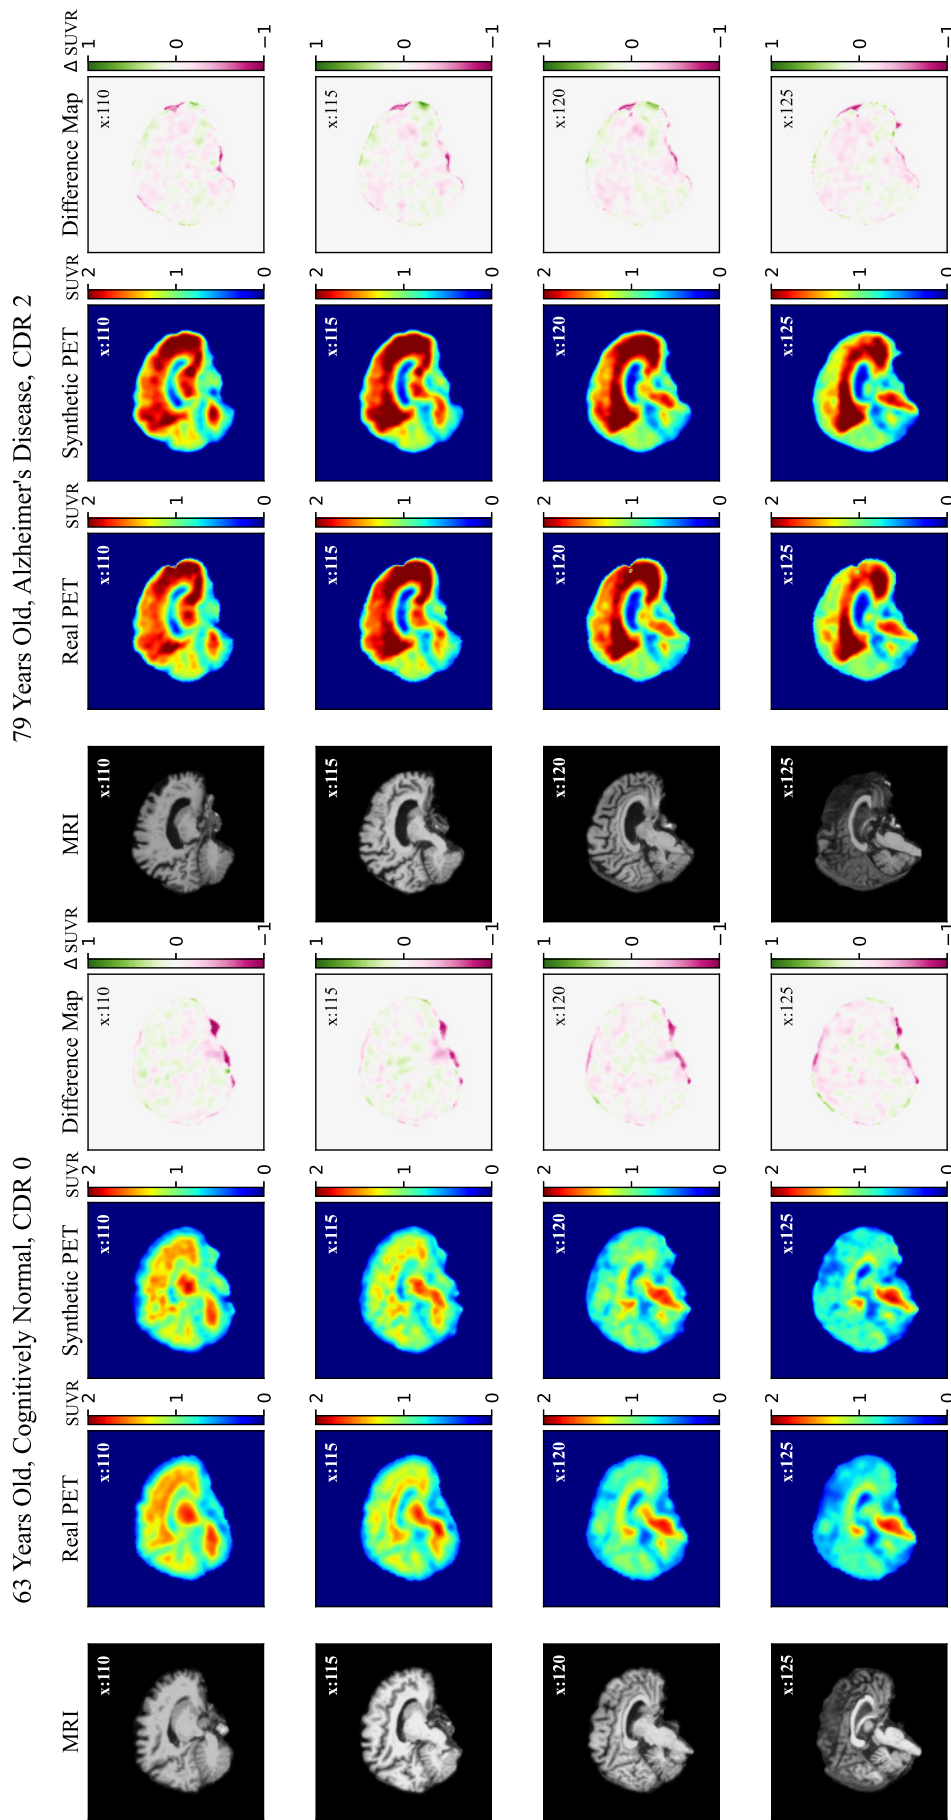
Sagittal Views from three-dimensional volume of MRI input, true PET label, synthetic PET and difference map between real and synthetic PET for cognitively normal (CN) and Alzheimer's Disease (AD) subject shows a higher concentration in the frontal lobe than the CN subject, the synthetic PET image has minor discrepancies with the true PET in regions with low levels of amyloid.
